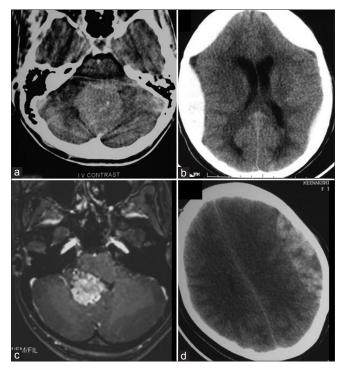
(a) Case 1, Axial CT scan showing midline posterior fossa tumor (b) Case 1, Postoperative CT scan showing a bilateral frontal and parietal EDH after posterior fossa surgery (c) Case 2, Contrast-enhanced MRI scan showing 4th ventricular choroid plexus papilloma (d) Case 2, Axial section of CT scan, performed after rapid closure of primary operative site, showing a massive mixed-density left-sided EDH
